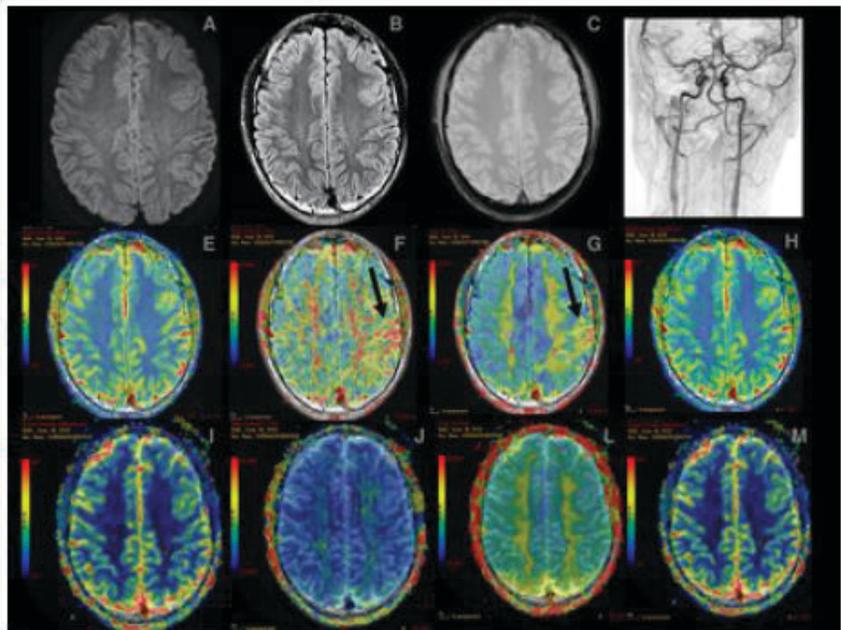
A-D demonstrated fast protocol to exclude recent ischemia or bleeding, with patency of large intracranial vessels and without significant changes in structural images (Diffusion, Gradient-Echo and FLAIR). E-H with the reconstructions of the perfusion study and highlighting the important increase in time to the plateau (TTP - figure G) and mean transit time (MTT - figure F), with no changes of the other parameters. I-M with the perfusion control study and characterizing the regression of the previously evidenced changes.
